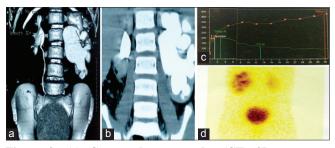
(a) Computed tomography (CT) 3D reconstruction shows a dilated pelvicalyceal system, (b) CT shows a functioning left kidney with thinned out renal parenchyma, (c and d) diethylenetriaminepentaacetic acid scan shows obstructed left kidney
